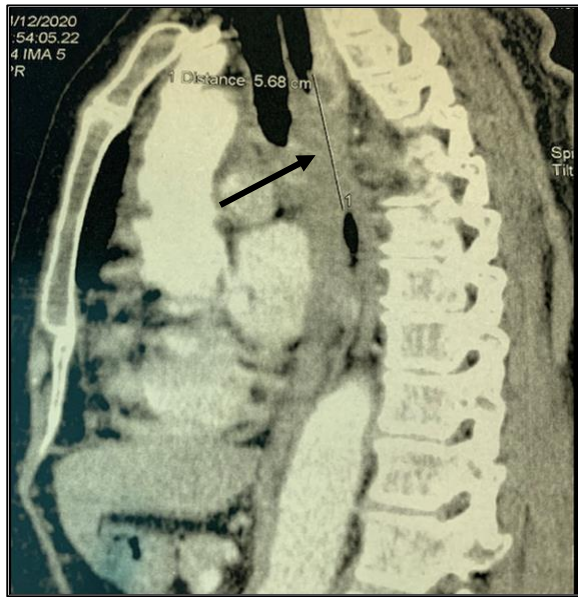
CT scan obtained before the operation shows a stricture caused by esophageal cancer in the middle thoracic portion of the esophagus.
